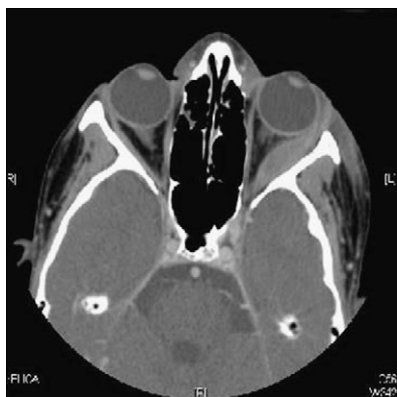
CT scan of the orbit revealing fusiform swelling of the left lateral rectus.
